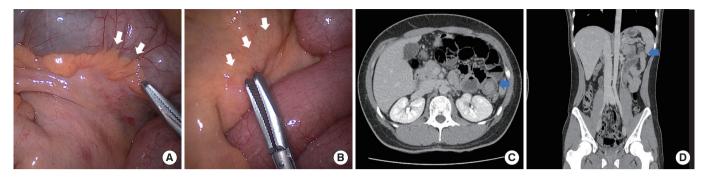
The operative findings of a 21 years-old male patient with small bowel obstruction diagnosed with Crohn disease. (A) Creeping fat sign and (B) mesenteric thickening due to fibrofatty proliferation of the mesenteric tissue adjacent to chronic inflammation of bowel loops (white arrows). (C, D) The abdomen computed tomography scan shows targetoid small bowel (blue arrows) which is intussusception.
